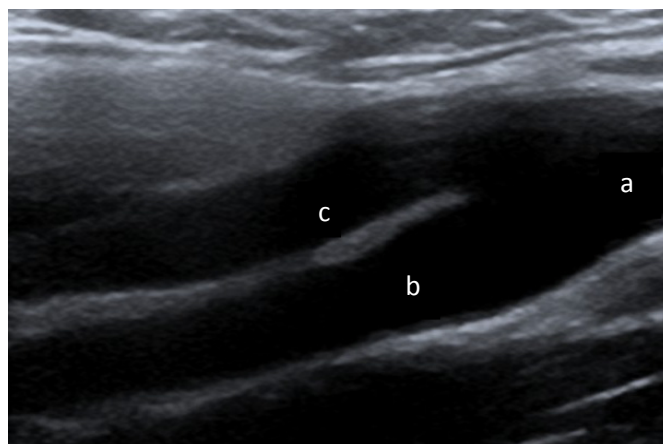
Carotid Ultrasound Technique.
